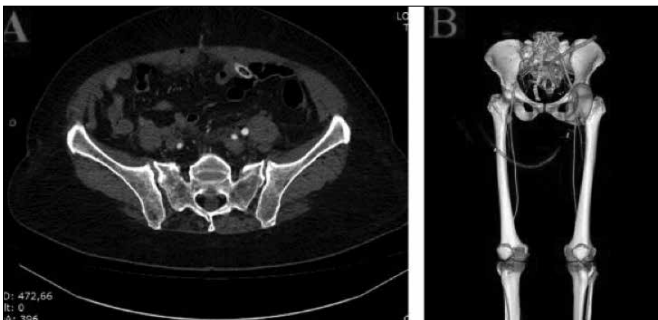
CT angiogram of the pelvis and upper legs (A) and CT angiogram with 3D reconstruction (B) show absence of flow in the right external iliac artery (white arrow) indicating arterial occlusion. Left external iliac artery is patent (white arrow head)
